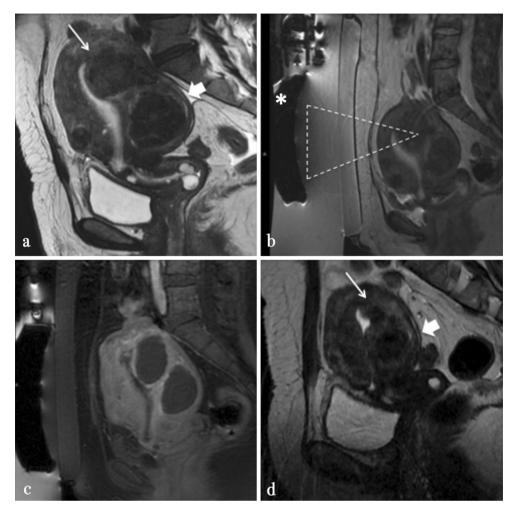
Magnetic resonance imaging findings at baseline and 24 months after MRgFUS treatment in a 47-year-old woman: a sagittal T2w image showing almost three fibroids, greatest intramural in the posterior uterus wall (*small arrow* and *large arrow*); b MR image during MRgFUS treatment: patient prone (feet
